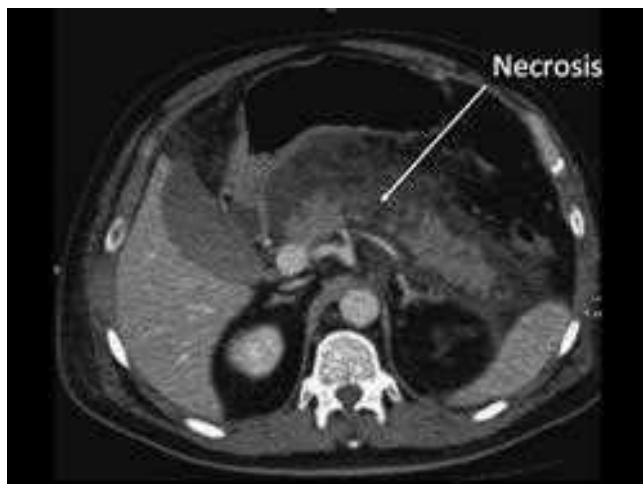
CT scan showing well perfused interstitial edematous acute pancreatitis of the neck and tail of the pancreas with a confluent area of necrosis of the pancreatic body. Pancreas surrounded by fluid, inflammation, and possible peripancreatic fat necrosis.
